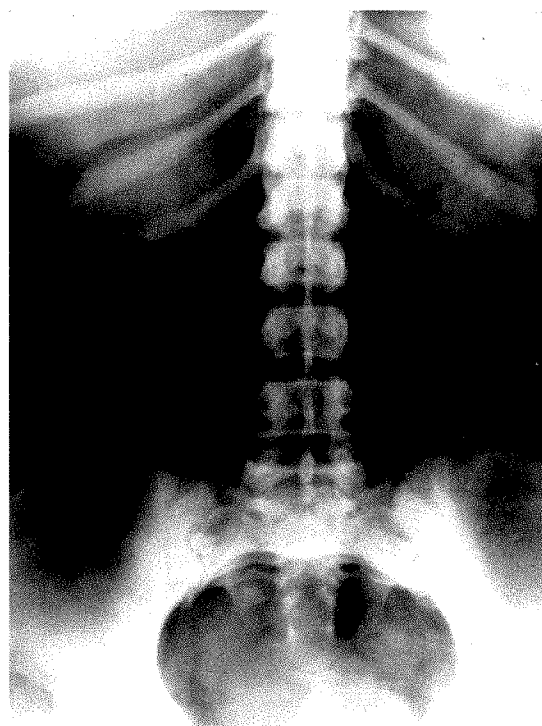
Supine roentgenogram of abdomen 18 months after cessation of recalcification therapy demonstrating normal skeletal density.
